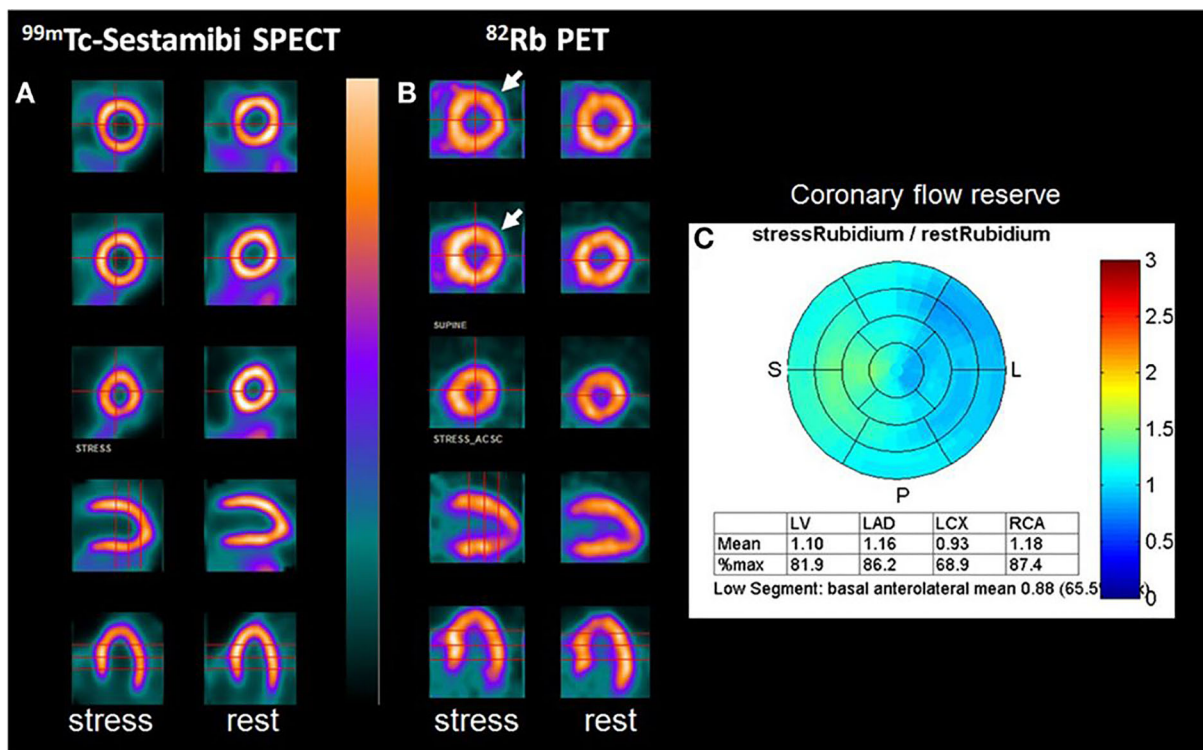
^{99m}Tc -sestamibi SPECT (A) and ^{82}Rb -PET/CT (B) studies performed in a 56-year-old woman. Ischemia involving the circumflex artery (*arrow*) was evident by ^{82}Rb -PET after administration of dipyridamole, demonstrating the superior sensitivity of this technique. Image
